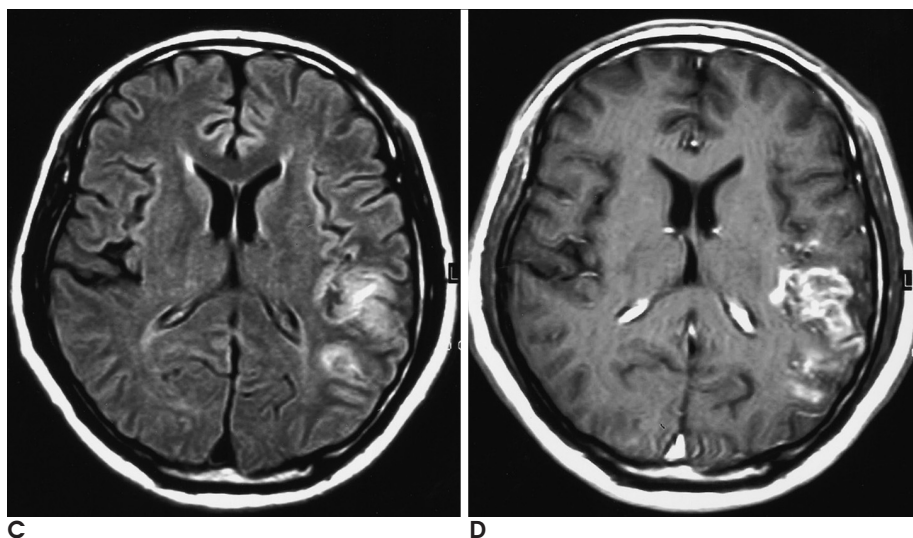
A. Axial T1-weighted image (TR/TE 520/30) revealed low signal intensity in the cortex and adjacent subcortical white matter of left parietal lobe.
